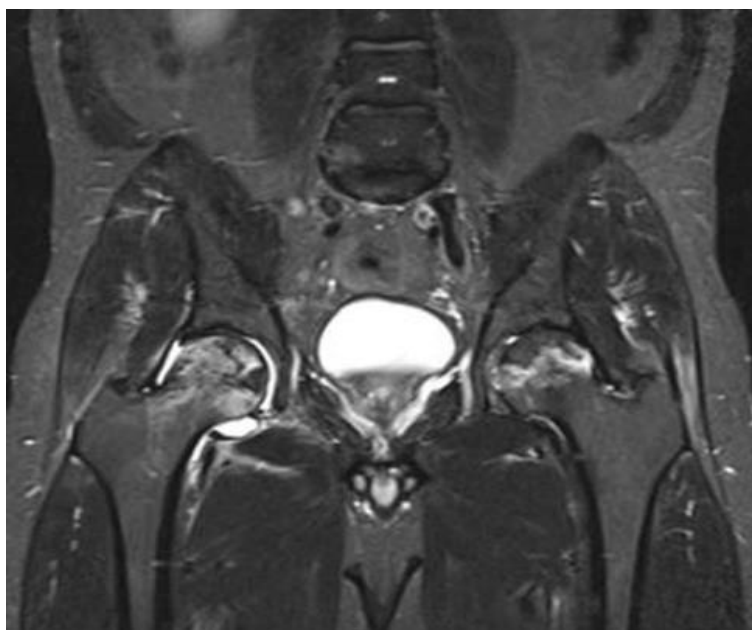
MRI-ONFH of the right hip 60% involvement.
